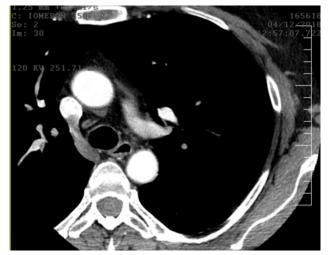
Computed tomography of the heart. Both esophagus and trachea are visible in this image. They are posterior structures being localized between the heart and the descending aorta.
